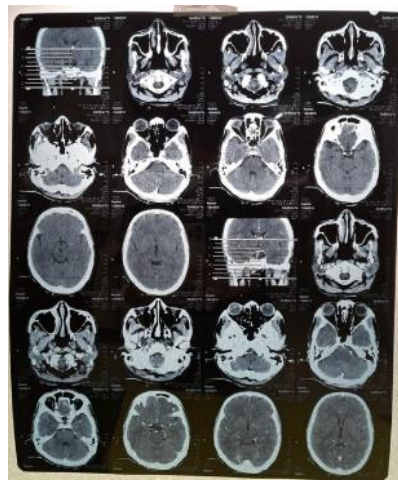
The result of CT-Scan
